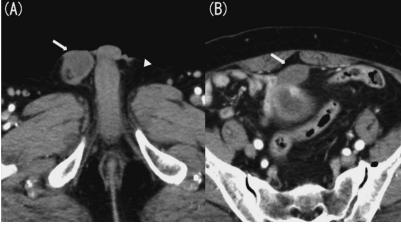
A: Contrast-enhanced computed tomography (CT) image (axial image, early phase) at the left inguinal region level.
